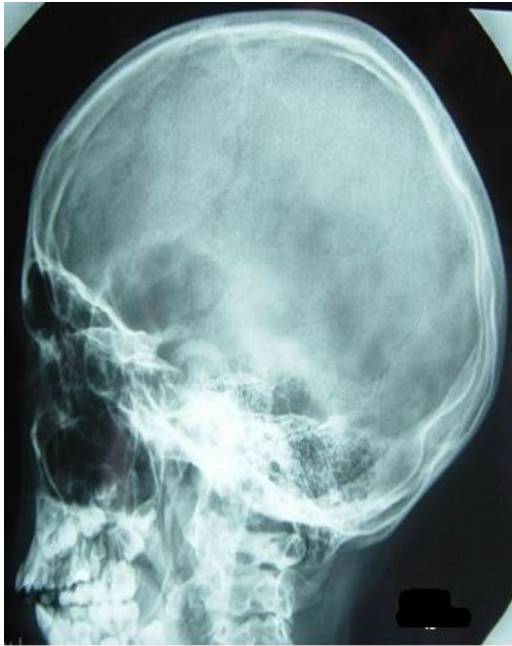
Lateral skull radiograph of the same girl with MPS type III showed sclerosis of the Calvaria and hyperostosis of the skull base with a large sella turcica.
